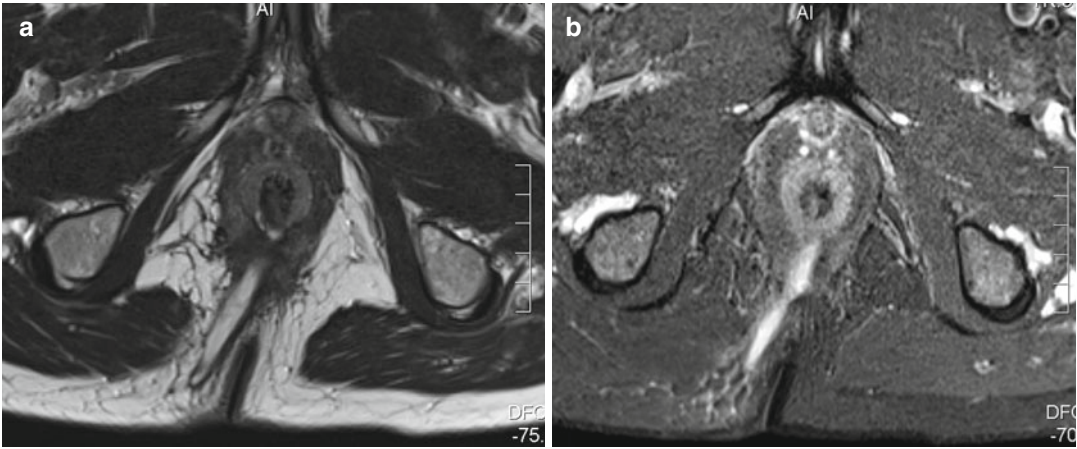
Axial T2-weighted (a) and STIR (b) images in a man with a transsphincteric fistula in the right posterior quadrant with an internal opening at 6 o'clock at dentate line level (same patient as Fig. 18.1)
